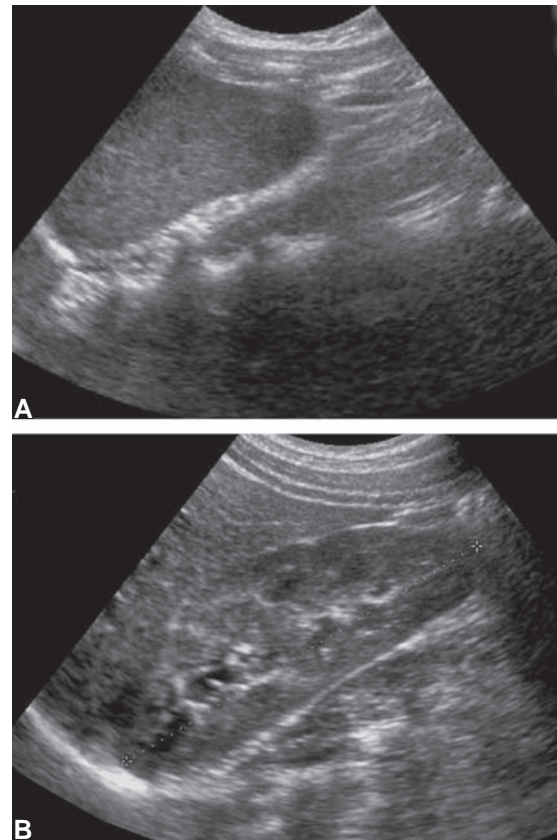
to C: Crossed fused renal ectopia. (A) Parasagittal ultrasound scan of right flank shows absent right kidney; (B) Parasagittal scan ultrasound scan of left flank shows a normally positioned left kidney (white arrow) with an apparent mass of renal tissue at its lower pole (black arrow). This is the ectopic right kidney; (C) DMSA renal scan demonstrates the ectopic right kidney lying medially and horizontally, attached to the lower pole of the left kidney
